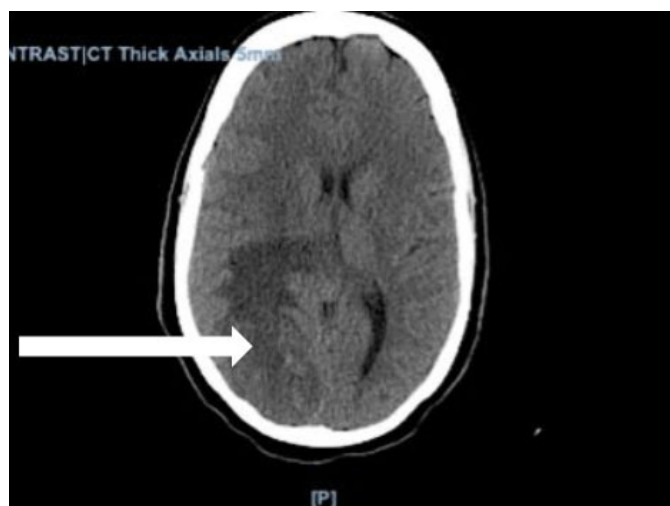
CT without contrast showing right-sided subacute hemorrhagic infarct of the parietal lobe with slight midline shift.
